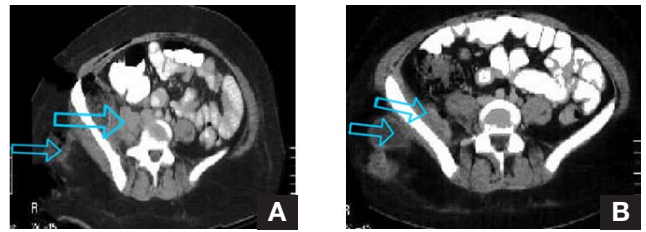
In case 2, (A) computed tomography (CT) scan obtained on admission showed large flank abscess extending around iliac wing, mostly subcutaneous and involving the gluteal muscles. (B) CT scan obtained 1 day after débridement revealed no residual fluid collection.
